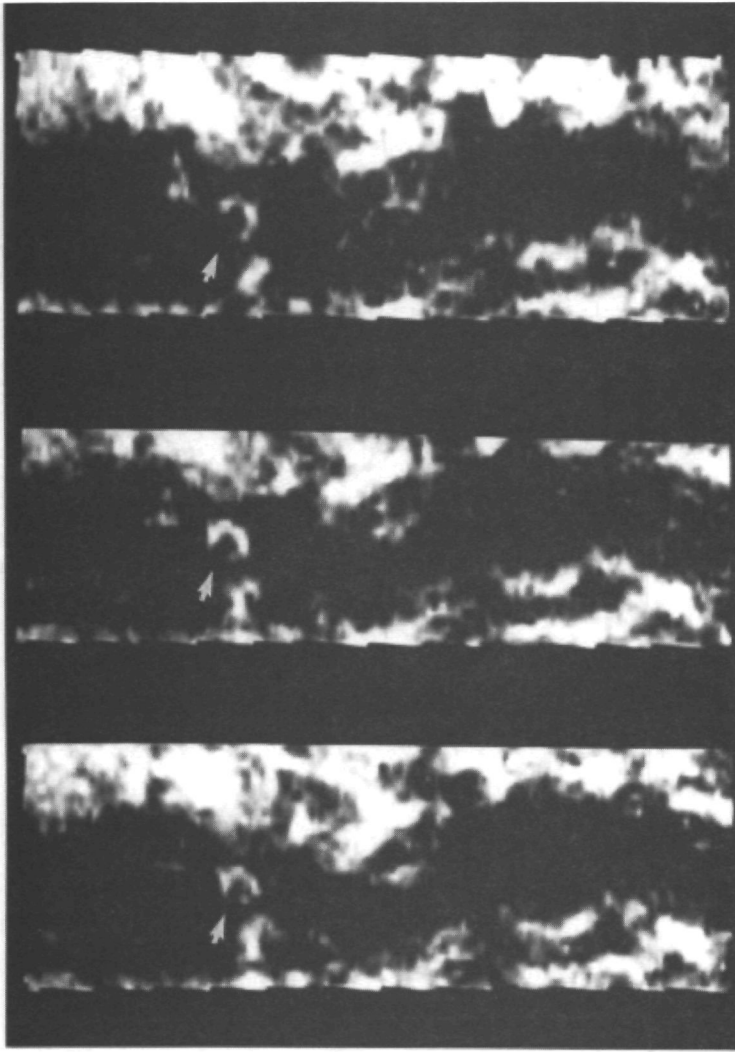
HRCT of the right ear. Postmeningitis deafness patient. Normal cochlear turns (arrows).
